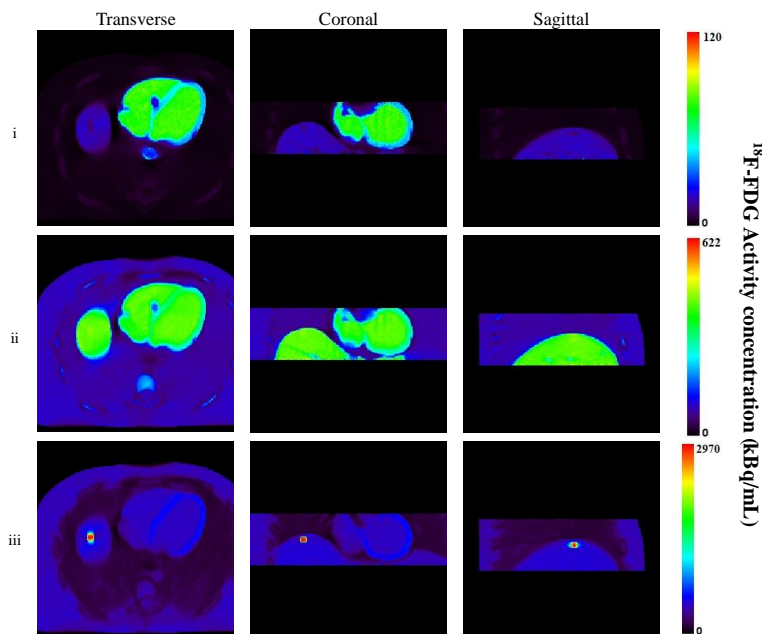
Transverse ,coronal and sagittal reconstructed  $^{18}\text{F}$ -FDG PET images taken at 3 different time points corresponding to i = frame 1, ii = frame 17 and iii = frame 28.
